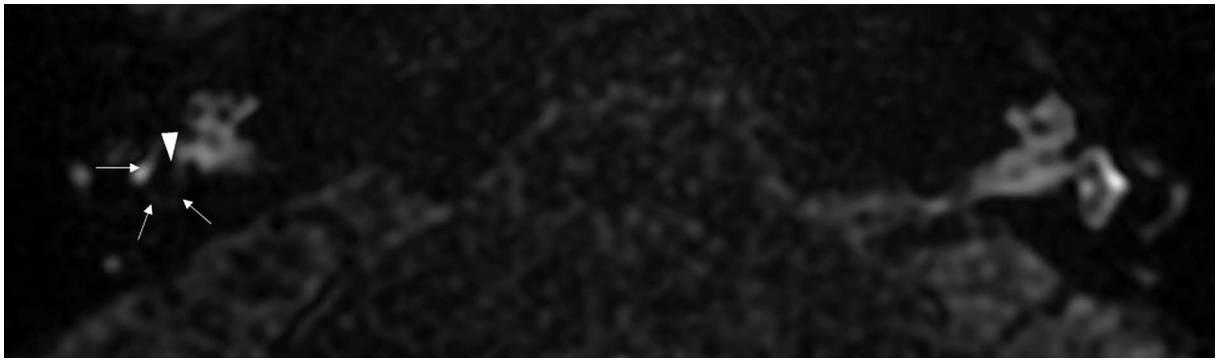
Magnetic resonance image of a 59-year-old female (patient #5) with right-sided clinically defined Ménière's disease. The example case of the mild vestibular hydrops – grade 2 in the Bernaerts scale [13] and grade 1 in the Barath grading system [11]. Delayed-postcontrast 3D-FLAIR T2 axial image of both ears below the mid-modiolar level (inferior part of the vestibule). On the right side, the saccule and utricle are enlarged and fused (arrowhead), but the enhancing rim of the vestibule's perilymphatic space is still visible (marked with arrows)
